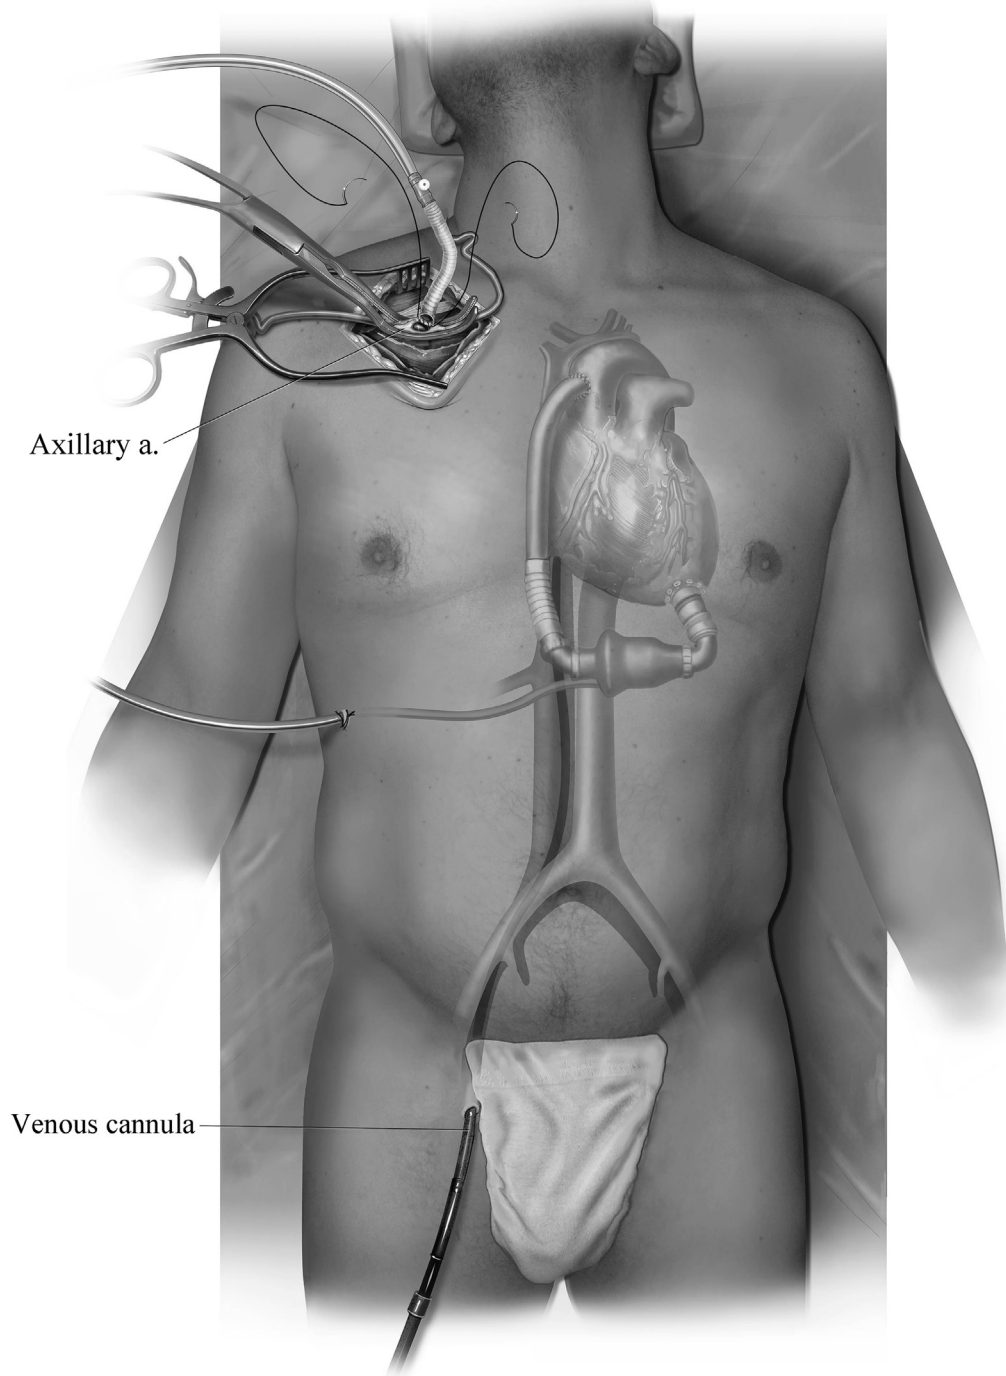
Peripheral cannulation. After a period of outpatient convalescence and end-organ recovery, the LVAD patient is considered for subsequent heart transplantation. Typically, the period of recovery between the LVAD procedure and heart transplantation is greater than 2 months. Preoperative chest CT should be obtained routinely to further define the anatomy before considering transplant. A suitable donor heart is matched to the recipient based on size, ABO blood type compatibility, and HLA antibody compatibility. Once the procurement operation has begun and the donor heart is visualized and determined to be suitable, the recipient LVAD removal and heart transplant procedure can be initiated. After general anesthesia, a radial arterial line and a right internal jugular Swan-Ganz catheter are placed. The Swan-Ganz catheter is left in the SVC during the procedure and floated into the pulmonary artery once the patient is weaned off cardiopulmonary bypass (CPB). After the patient is positioned, and the skin prepared, peripheral cannulation for CPB is established before the reoperative sternotomy. Although reoperative sternotomy can generally be performed without injury to vascular structures, peripheral cannulation adds safety. Although there are many options for peripheral cannulation, we prefer cutting down the right axillary artery and application of an 8-mm Hemashield graft in an end-to-side configuration to provide arterial inflow for CPB. Venous drainage for CPB is established percutaneously by accessing the right common femoral vein. Intraoperative transesophageal echocardiography (TEE) is used to confirm the position of the guide wire introduced from the right femoral vein and guided into the right atrium. This site is sequentially dilated, and then a #25 French multistage venous cannula is guided over the wire into the right atrium. Before these cannulation procedures, the patient should be systemically administered heparin. Importantly, after initiating CPB, the LVAD pump speed should be decreased to avoid generation of negative pressure in the LV, which could lead to air entrainment and subsequent embolization. However, the LVAD pump should not be turned off if the outflow graft cannot be clamped, as regurgitant flow will occur, and may lead to LV distention. CT = computed tomography; HLA = human leukocyte antigen; SVC = superior vena cava; LV = left ventricle.
